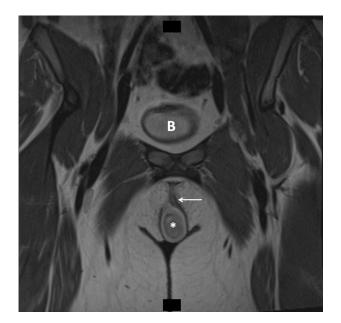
T2 MRI of the pelvis. Coronal reconstruction demonstrates the location of the periclitoral mass (asterisk) in relationship to the bladder (B). Note leftward displacement of the clitoral bodies (arrow).
